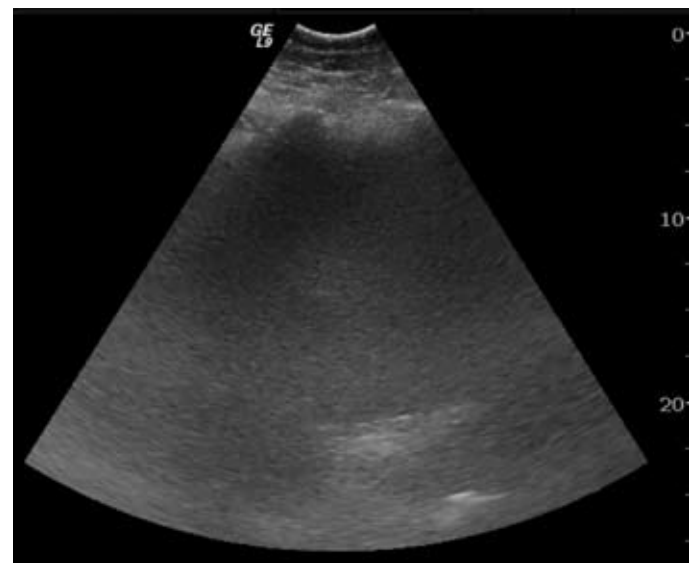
Ultrasound examination of the liver in an obese patient shows a non-diagnostic image due to the attenuation of sound as it passes through the thickness of the soft tissue fat. None of the internal structures of the liver (biliary ducts, vessels) can be seen.
